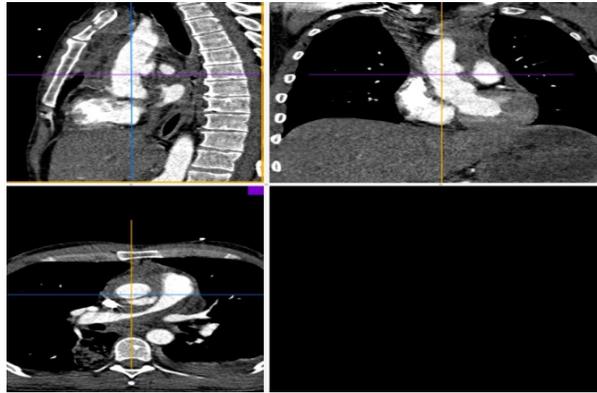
Thoracic CT after injection of the contrast product in axial and sagittal section showing a traumatic aneurism image of 2.2 cm at the posterior wall of the ascending aorta.
